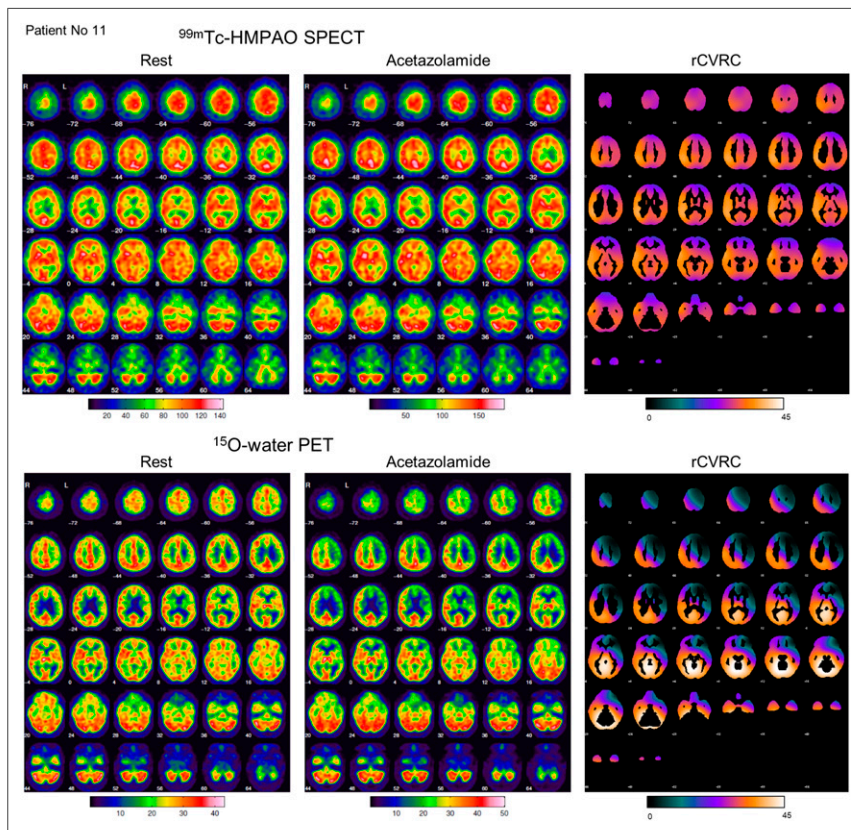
Standardized display to support visual interpretation of $^{99\text{m}}\text{Tc}$ -HMPAO SPECT (top) and ^{15}O -water PET (bottom) with respect to impairment of rCVRC.
